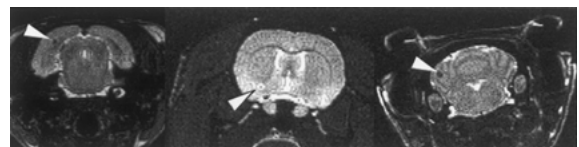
Detection of ENU-induced brain tumors. Transplacental ENU-induced tumors (50 mg/kg on day 21 of pregnancy) were detected by imaging with T2-weighted MRI. Representative images of several different small early tumors, showing a low signal intensity core mass with a hyper-intense peripheral ring.
